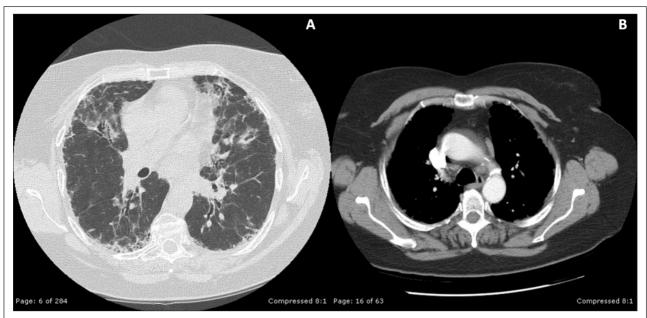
CT scan of the same patient 5 years after diagnosis. A) Septal thickening and traction bronchiectasis seen predominantly in the subpleural areas of both lungs. B) Mediastinal lymphadenopathy is still evident.
